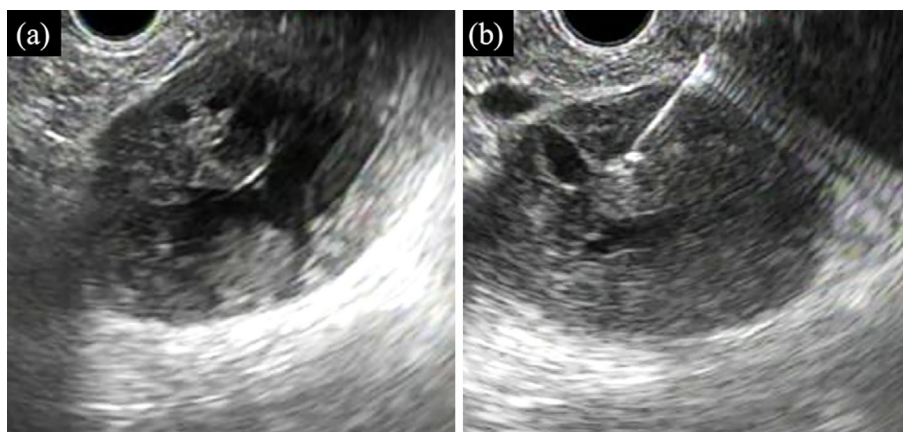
Endoscopic ultrasound (EUS) findings. EUS via a gastric approach detected a 38 mm diameter mass adjacent to the left adrenal gland. The surface was smooth with cystic degeneration; however, there was no obvious calcification (a). EUS-FNA was performed via the gastric approach, and two passes were made using a 22-gauge needle (b).
